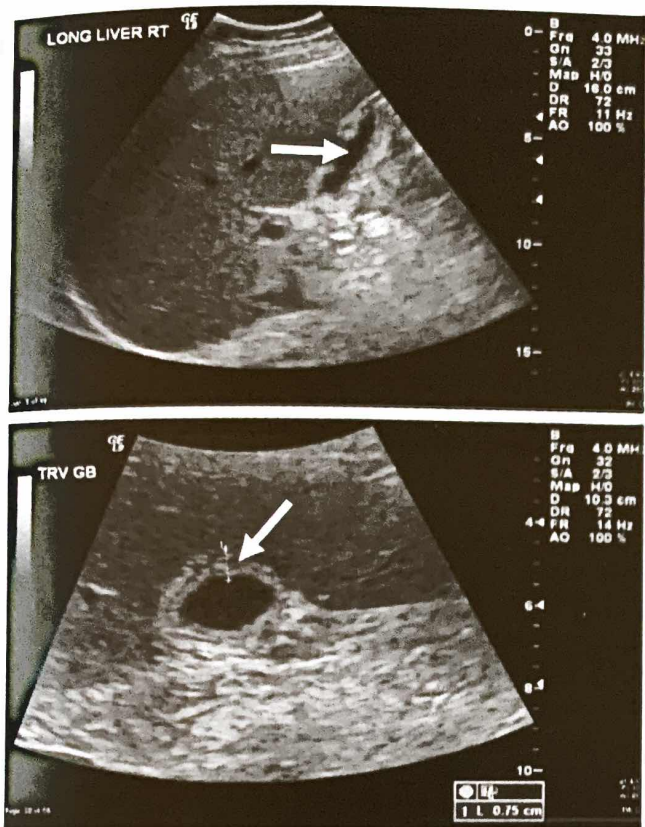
Gallbladder ultrasound consistent with acalculous cholecystitis showing a thickened gallbladder wall (*bottom*), pericholecystic fluid (*top*), and an absence of gallstones or sludge.
